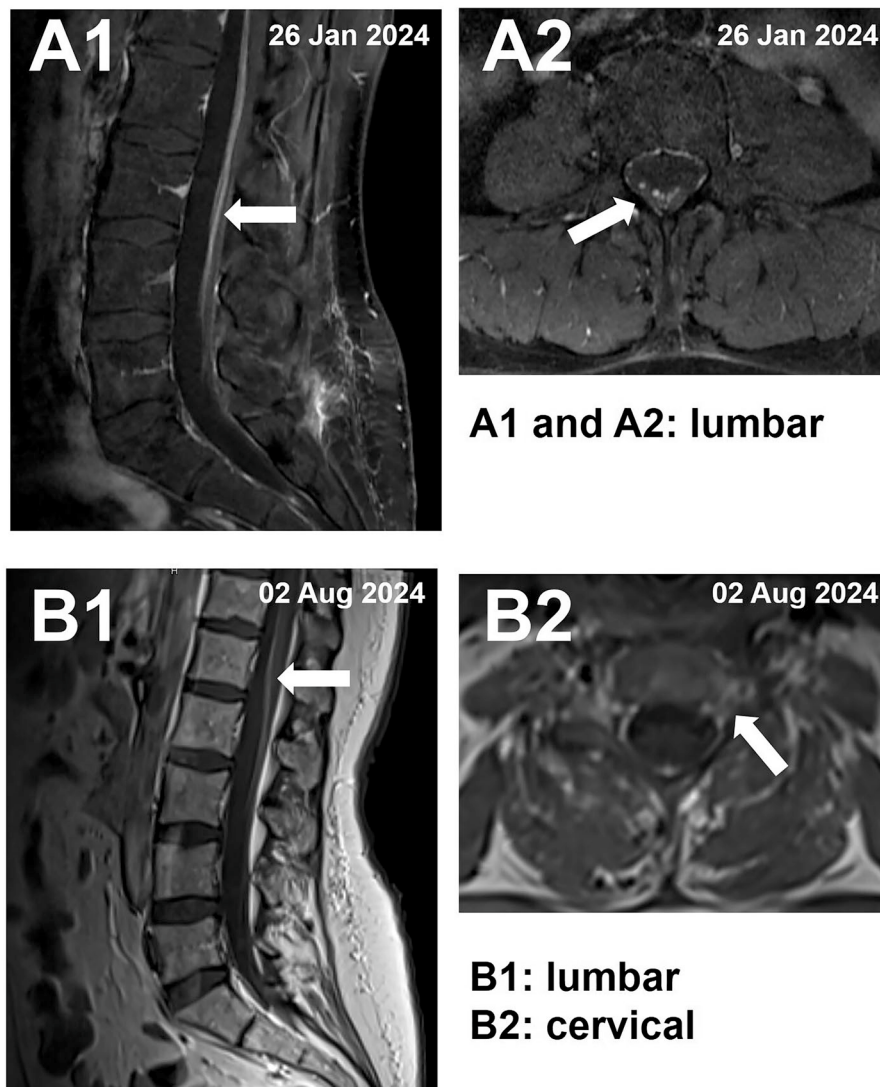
MRI findings. Arrows indicate contrast enhancement. Images A1 and A2 stem from the first MRI in 01/2024, images B1 and B2 stem from a follow-up MRI in 08/2024 after immunosuppressive treatment
